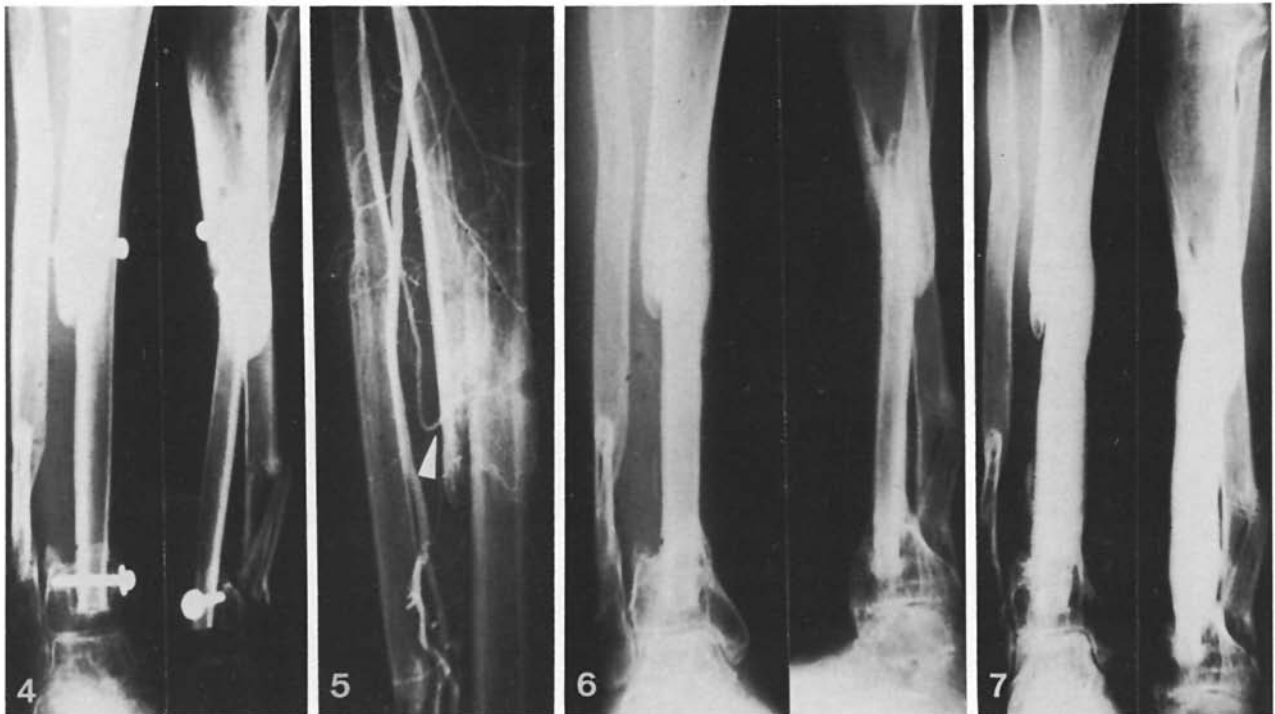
Radiographs at 3 months post-op.
